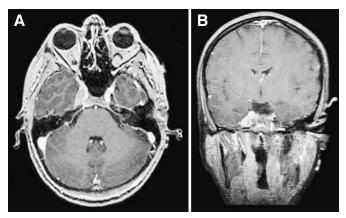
Axial (A) and coronal (B) postcontrast T1-weighted MRI scans demonstrating the enhancing lesion in the right cavernous sinus.
